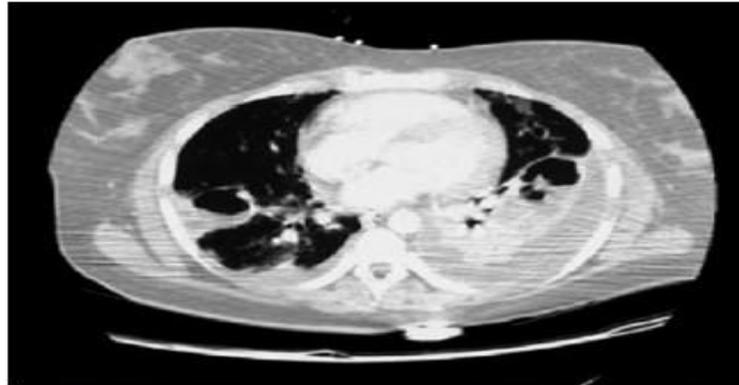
Necrotizing pneumonia on chest CT showing multiple bilateral nodules and cavitation, lower left lobe consolidation, and pleural effusion in a patient with methicillin-resistant *Staphylococcus aureus*.
